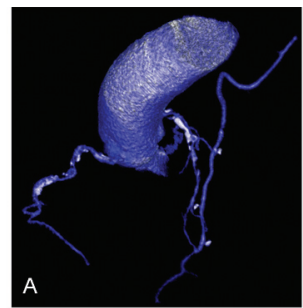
Postoperative bypass multislice computed tomography angiography allows an assessment of graft patency.
